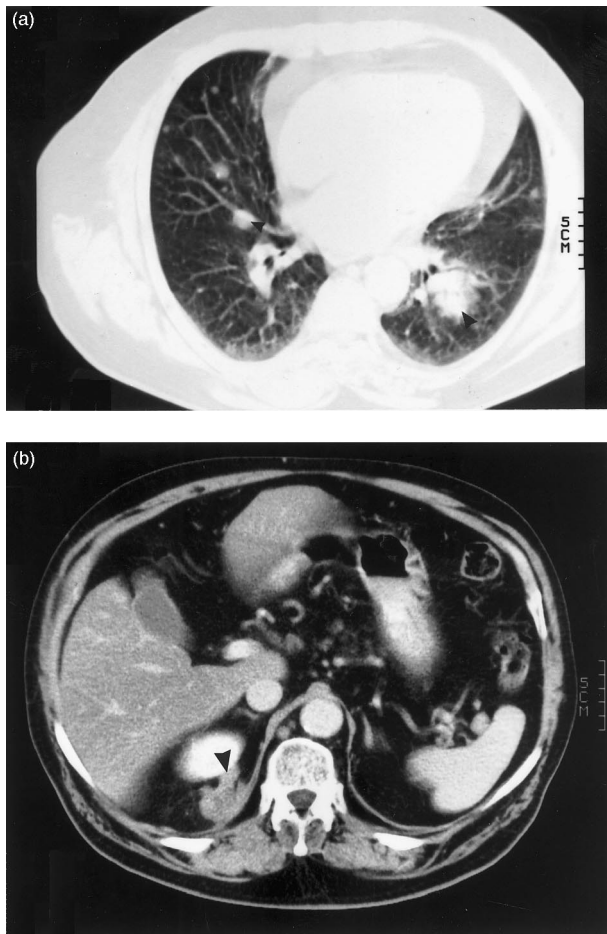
(a) Continuous 10 mm axial CT scans through the thorax showed a metastasis located centrally in the left lung (large arrow) and multiple smaller metastasis in the right lung parenchyma (small arrow). (b) Contrast enhanced continuous axial CT scans through the abdomen and pelvis revealed a tumour located between the apical part of the right kidney and the diaphragm (arrow).
